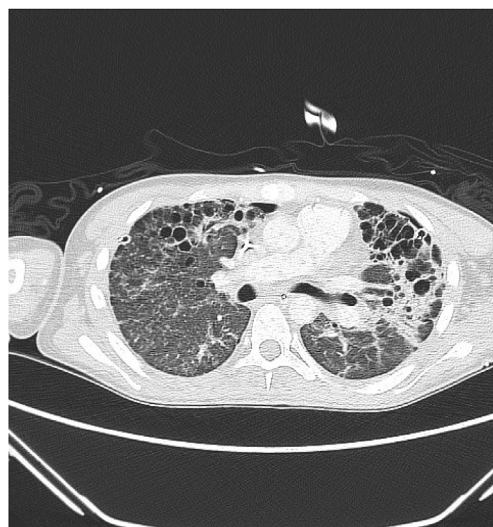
A CT scan after 46 days on ECMO. Both lungs have expanded with functional lung tissue visible again. This correlated with improvement clinically.
